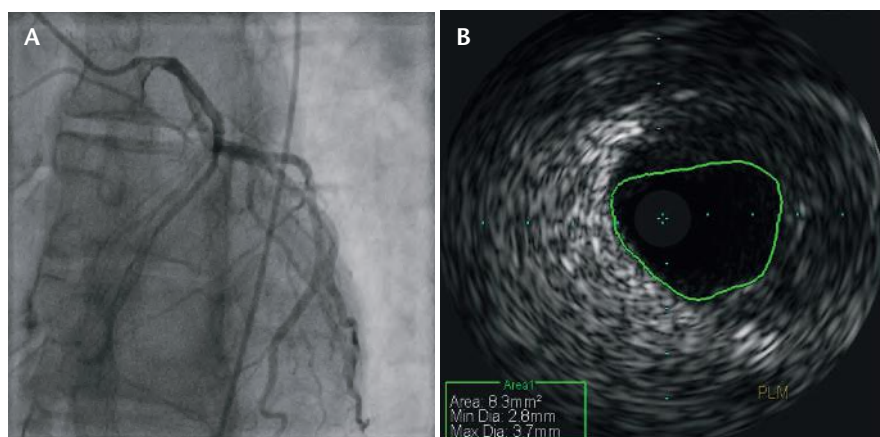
(A) Dissection of the left main coronary artery extending into the left anterior descending artery, with an 80% obstruction of the distal left anterior descending artery. (B) Dissection of the left main coronary artery confirmed via intravascular ultrasound.
